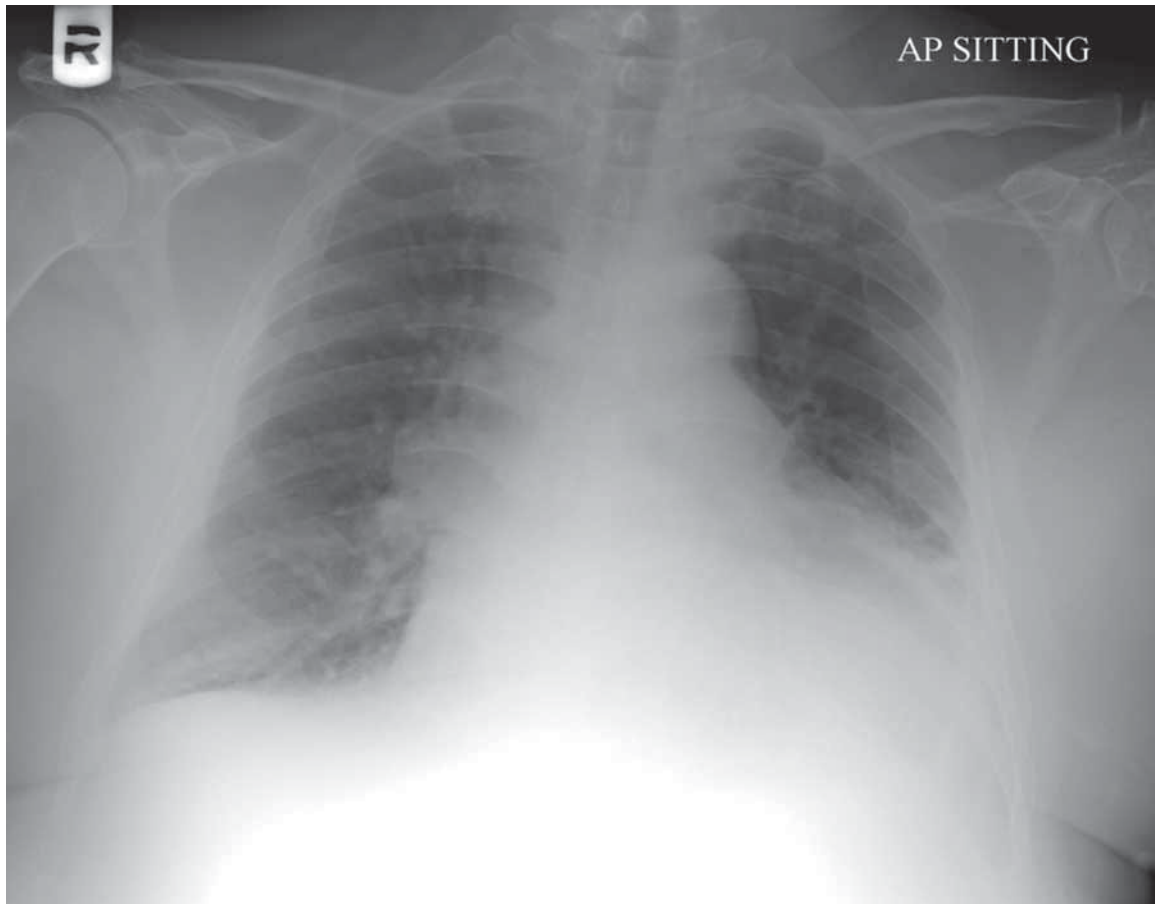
Chest radiograph: increased alveolar shadowing both lower zones with a left pleural effusion.
